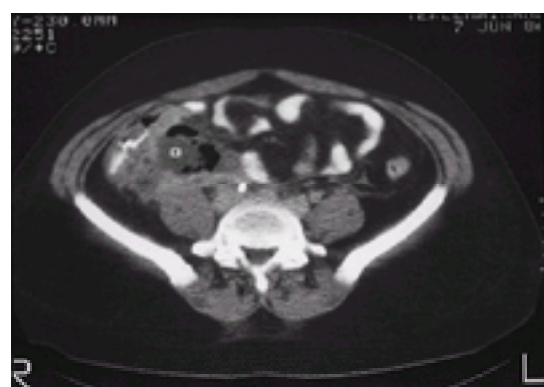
CT scan demonstrating retrocecal appendiceal abscess (marker).
